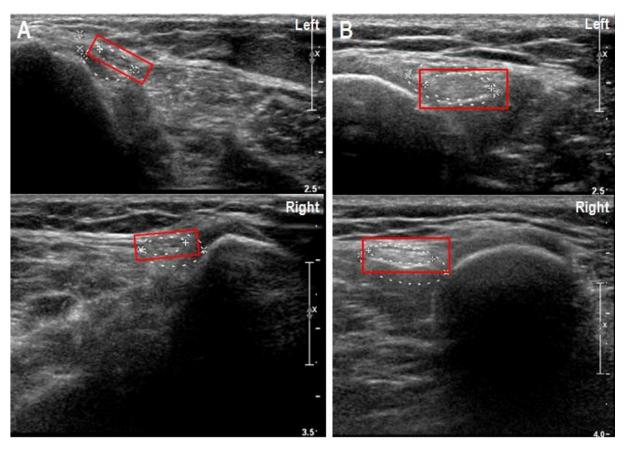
A. On the ultrasound of a patient with a low BMI, the nerve (indicated by the red rectangle) appears more hypoechoic and thinner. B. The ultrasounds of a patient with a high BMI shows a hyperechoic and thicker nerve (indicated by the red rectangle).
